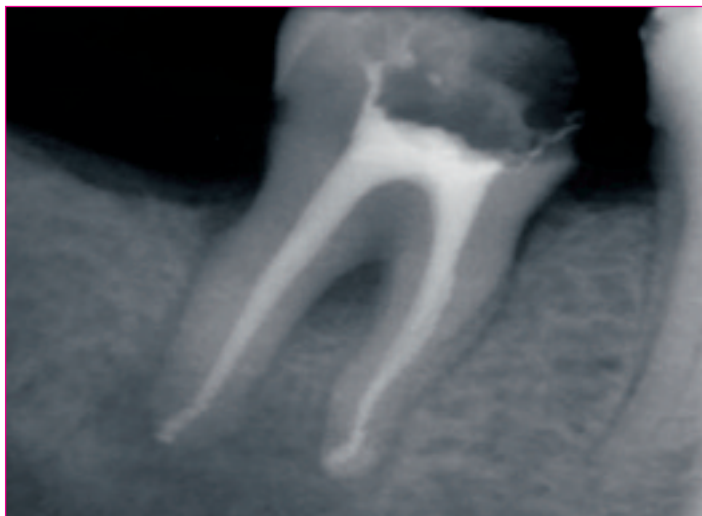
Immediate post-op radiograph shows a "successful" root treatment of a calcified canal.
